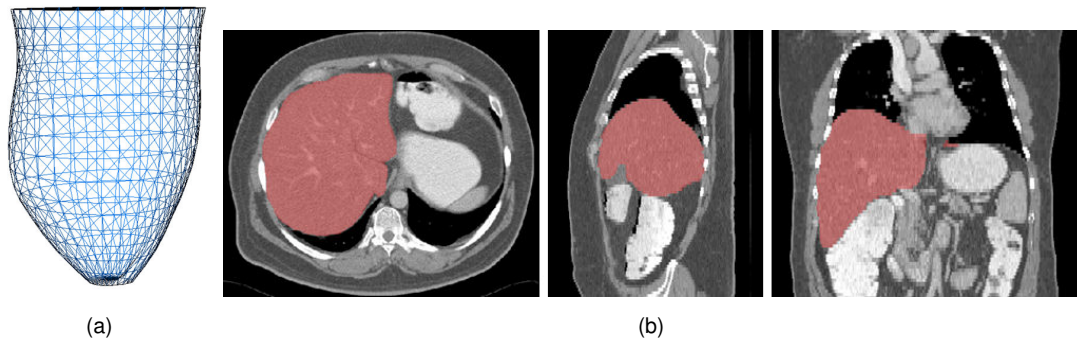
(a) An organ model of the cardiac left ventricle represented by a three-dimensional point cloud and visualized by a polygonal tessellation. (b) Manually created binary segmentation of the liver shown as an overlay with the original CT image in three cross-sectional views.
